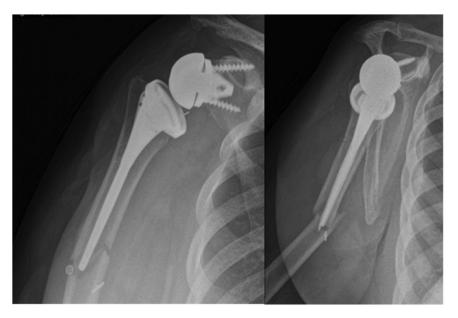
X-rays showing a periprosthetic humerus fracture at the tip of the stem.
